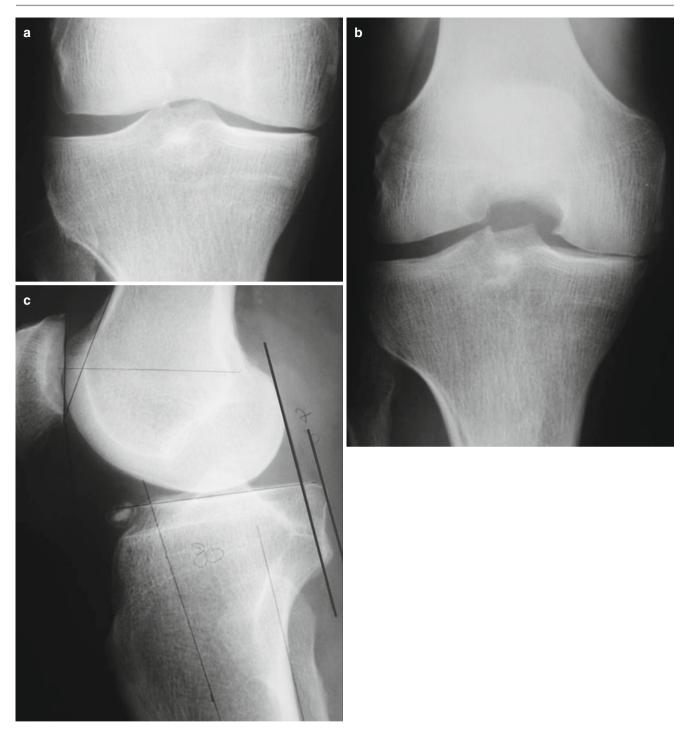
X-ray findings. (a) AP view. (b) Schuss view. (c) Lateral view
